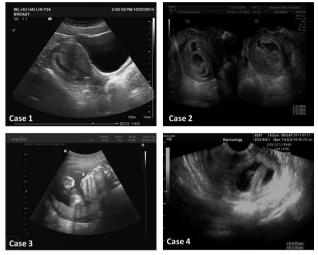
Antenatal ultrasound presentations of SCH in four cases.
